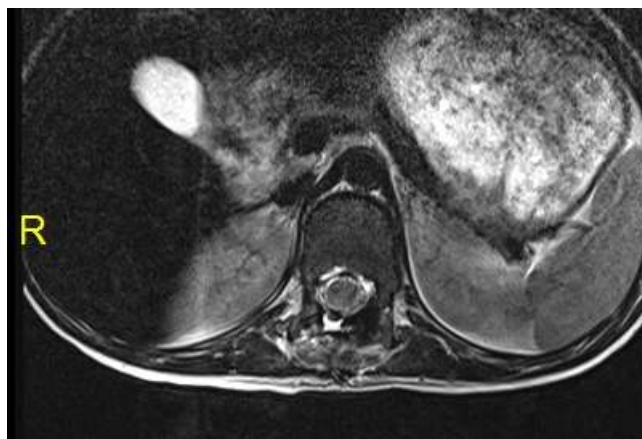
Post-operative MRI – Axial
